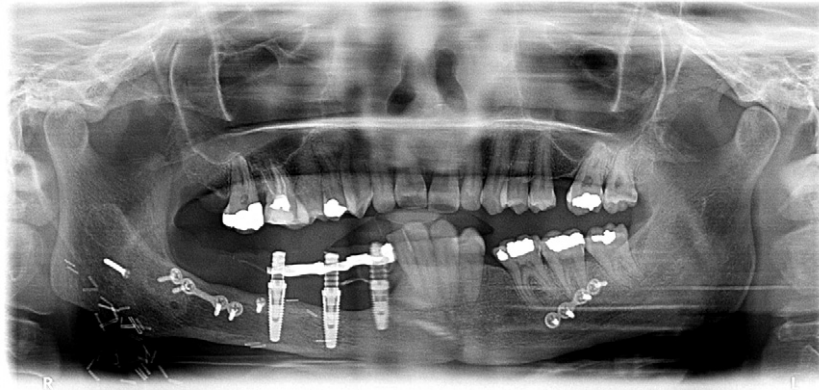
Panoramic radiograph after immediate loading.
